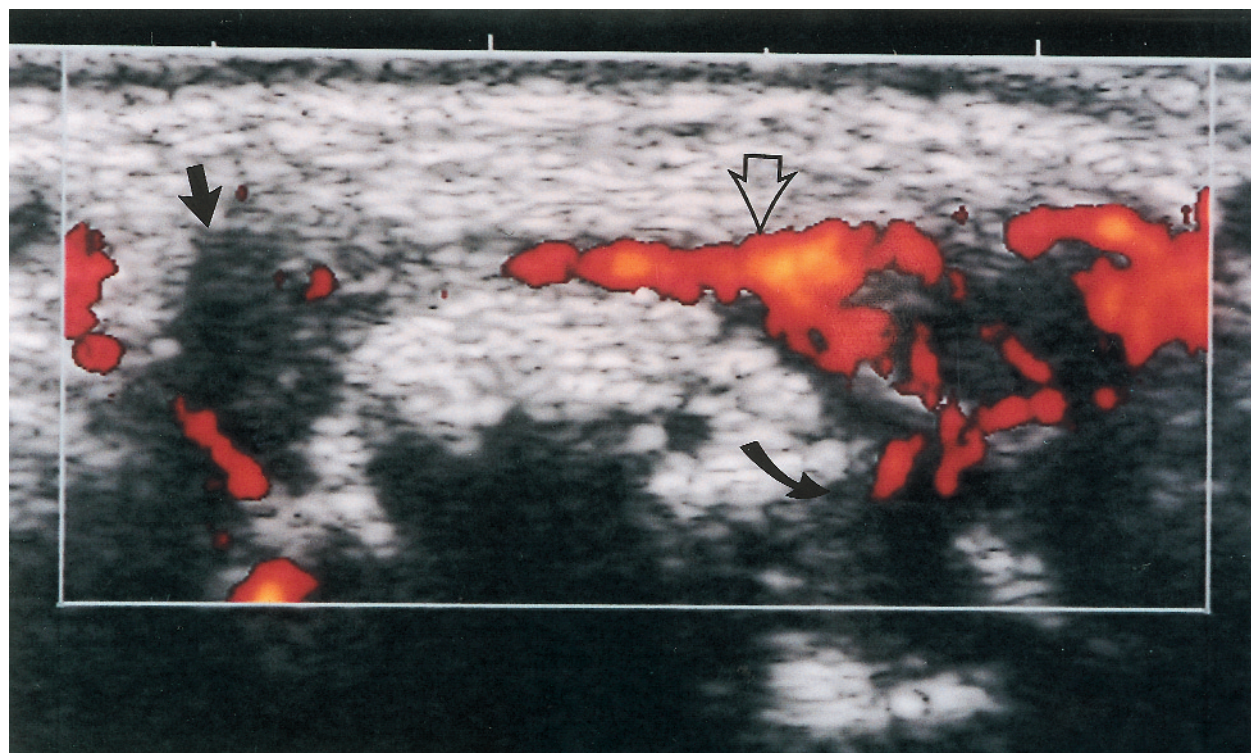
Transverse image of the 2nd MCP joint of a 43-year-old woman with RA presenting with joint pain and swelling. Thickened irregular synovium (straight arrow) with large bony erosion (curved arrow) is visible along the radial aspect of the joint surface. With power Doppler there is evidence of active synovitis (open arrow); power Doppler grade 2.
